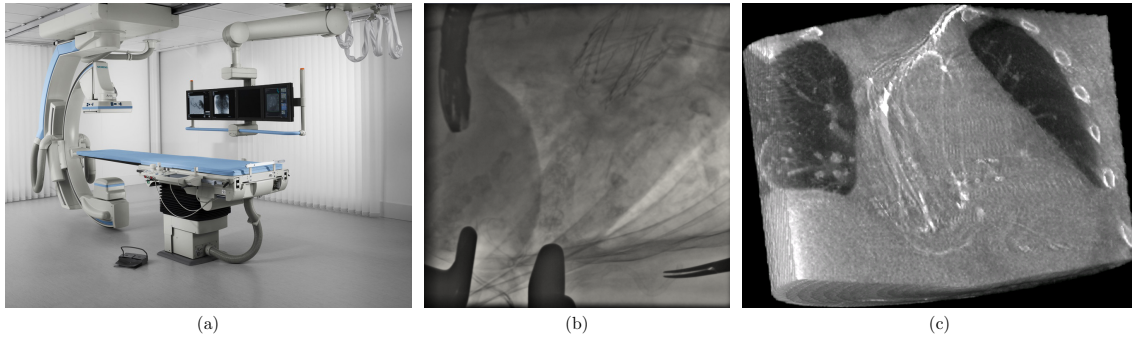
(a) Siemens Zee robotic C-arm mounted interventional X-Ray system; (b) Typical X-Ray fluoroscopy (XR) image of a cardiac intervention: marginal contrast for soft tissue, low contrast for bones, excellent contrast for metallic tools, devices and implants; (c) Volumetric reconstruction of cardiac C-arm CT image.
